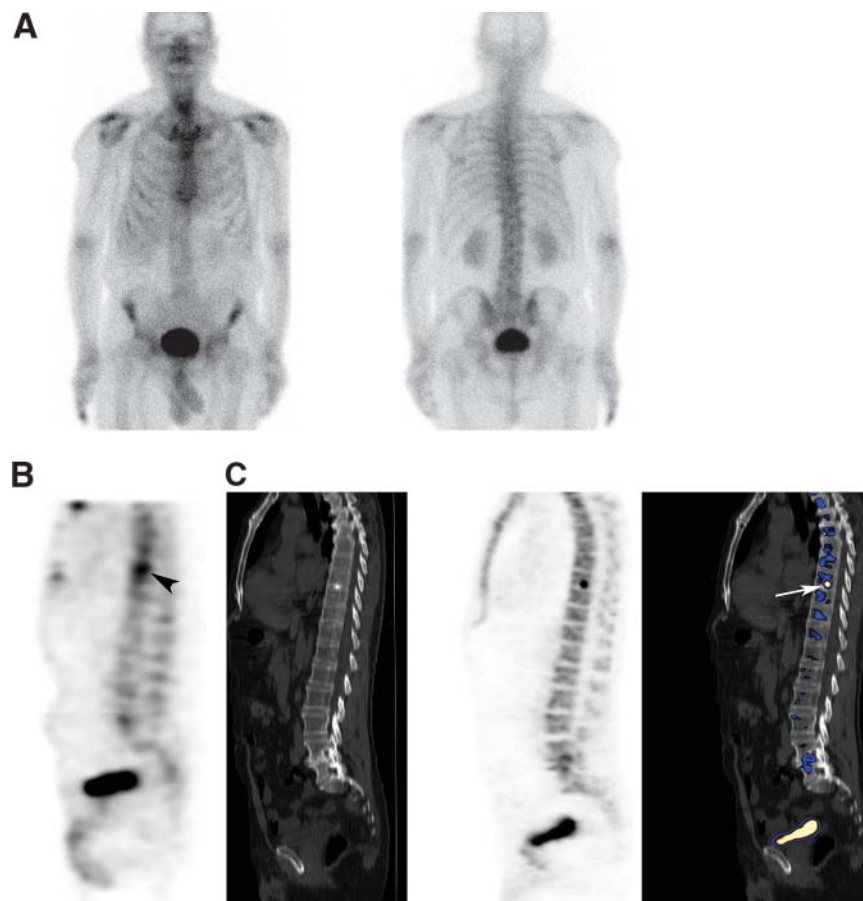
A single metastasis missed on planar BS in 63-y-old patient with prostate cancer at diagnosis. (A) Anterior and posterior planar BS, which was interpreted as negative for bone metastases. (B and C) Osteoblastic metastasis in D8 vertebra identified on SPECT (B) and on ^{18}F -Fluoride PET/CT (C). From left to right: SPECT (metastasis marked by arrowhead), CT, ^{18}F -Fluoride PET, and fused ^{18}F -Fluoride PET/CT (metastasis marked by arrow).
